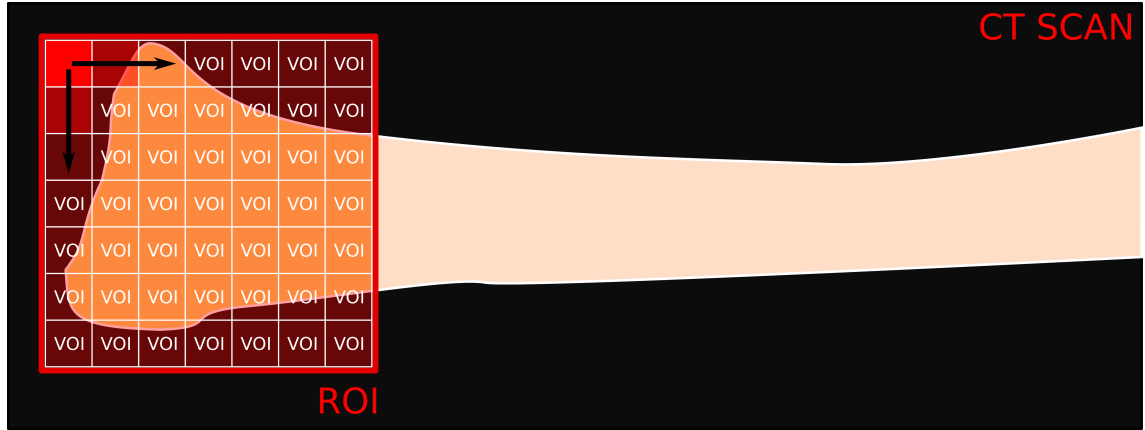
Definition of ROI and VOI at the example of a radius CT scan. The ROI defines a region inside the CT scan which is used for further analysis. In this example the distal part of the radius was selected as ROI. Inside the ROI, many VOI are used to calculate certain values, for example the BVTv. In this case cubic and adjacent VOI are used.
